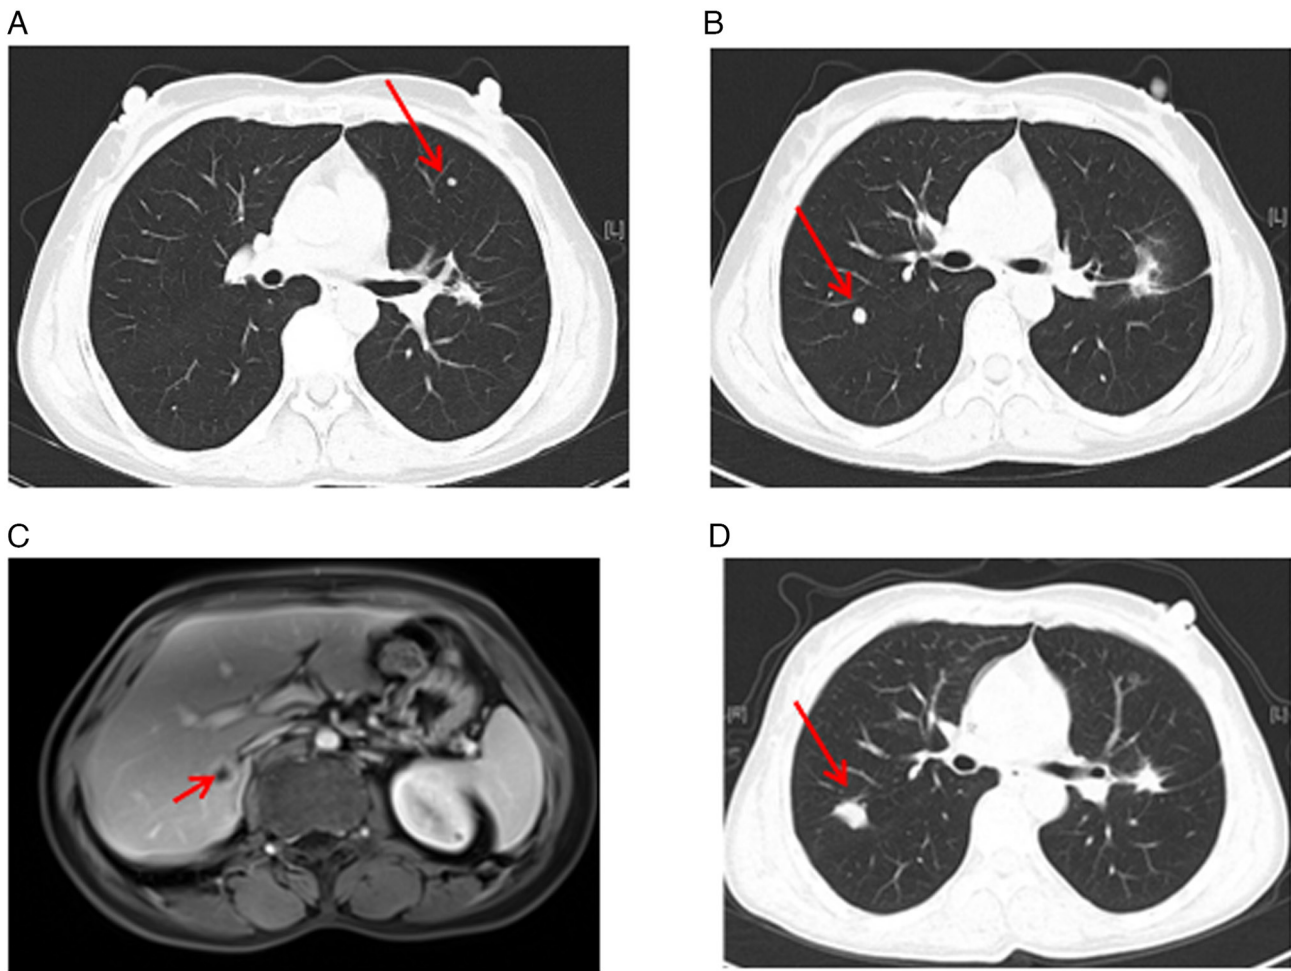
Enteric adenocarcinoma in right lung and the second liver metastasis. (A) Arrow points at a newly enlarged small pulmonary nodule in the right lung on thoracic contrast-enhanced CT scan in May 2021. (B) Arrow points at another newly enlarged small pulmonary nodule in the right lung on thoracic contrast-enhanced CT scan in May 2021. (C) During the routine enhanced MRI review of the abdomen in May 2021, a new lesion suggesting liver metastasis (arrow) was discovered behind the original liver metastasis. (D) A thoracic contrast-enhanced CT in February 2022 indicated good ablation on the nodule in right lung (arrow) after 10 months.
